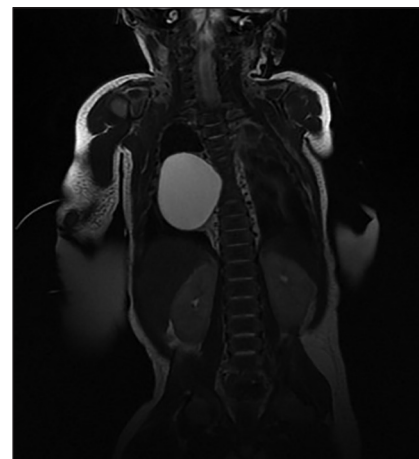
Magnetic resonance imaging, coronal section-demonstrating cystic mass in right hemi-thorax
